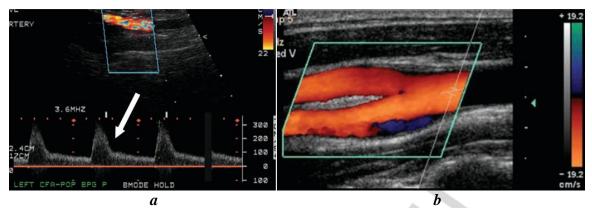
Duplex ultrasound: a — pulse wave; b — red color shows high velocity arterial flow
